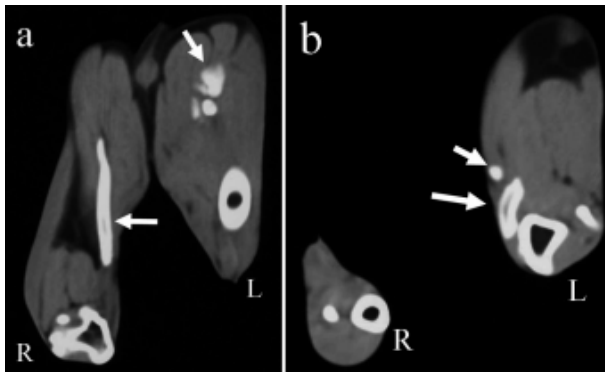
Cross-sectional computed tomographic (CT) findings of the pelvic limbs at the thigh (a) and crural (b) level. White arrows indicate multiple ectopic mineralization in the intermuscular areas.
